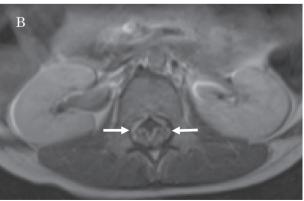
Sagittal T1-weighted (TR600/TE11) (A) and axial T1-weighted (TR513/TE11) (B) magnetic resonance images after gadolinium injection showed marked enhancement of the cauda equina and ventral nerve roots (arrows), consistent with GBS [Baran GA et al. AJR Am J Roentgenol 1993;161:161–3].
